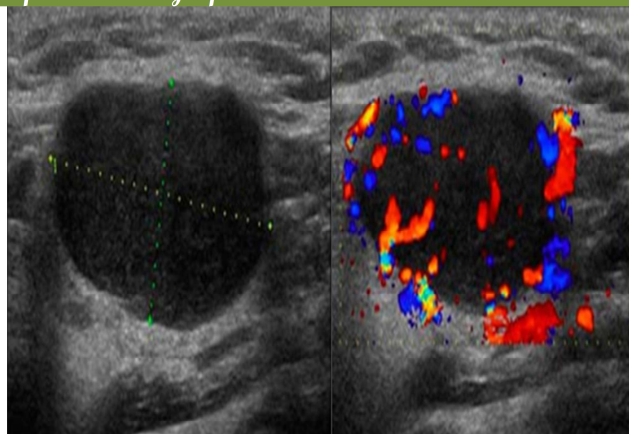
Ultrasound showing enlarged, hypoechoic, loss of fatty hilum lymph node showing diffuse predominantly peripheral vascularity consistent with metastatic node
